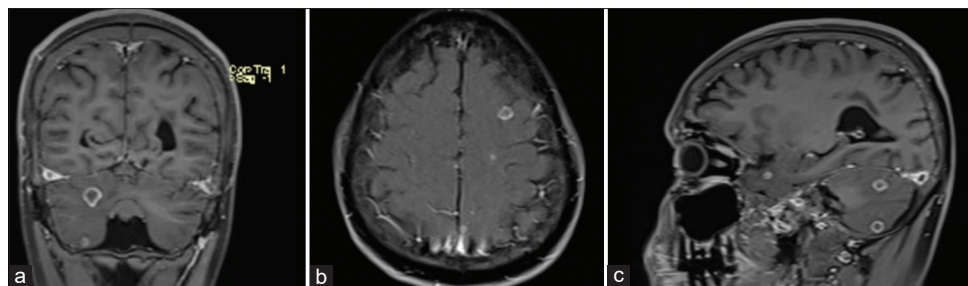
(a) Contrast-enhanced magnetic resonance imaging (MRI) brain (coronal section) showing multiple small ring-enhancing lesions in the left cerebellar hemisphere with surrounding perilesional edema; (b) Contrast-enhanced MRI brain (axial section) demonstrating multiple small ring-enhancing lesions involving bilateral cerebral hemispheres with surrounding perilesional edema and no evidence of meningeal enhancement; (c) Contrast-enhanced MRI brain (sagittal section) revealing multiple small ring-enhancing lesions in the left cerebellar hemisphere with surrounding perilesional edema
